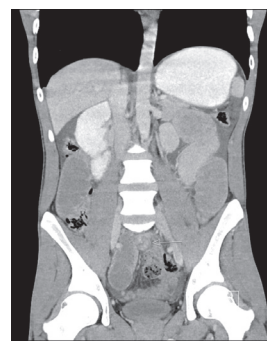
coronal CT scan showed a well circumscribed mass with calcifications (arrow) and dilated bowel loops.
